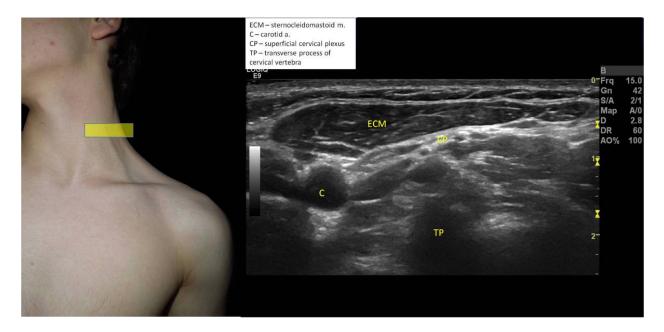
Superficial cervical plexus Ultrasonographically, it may be identified by placing the patient with neck rotated to opposite side, placing the probe on the cricoid and sliding laterally to the border of the sternocleidomastoid. It is located in the posterior cervical triangle, defined by the sternocleidomastoid, trapezius muscle and clavicle. The pavement is composed by the: splenius muscle, levator scapulae and scalenus anterior and medium.
